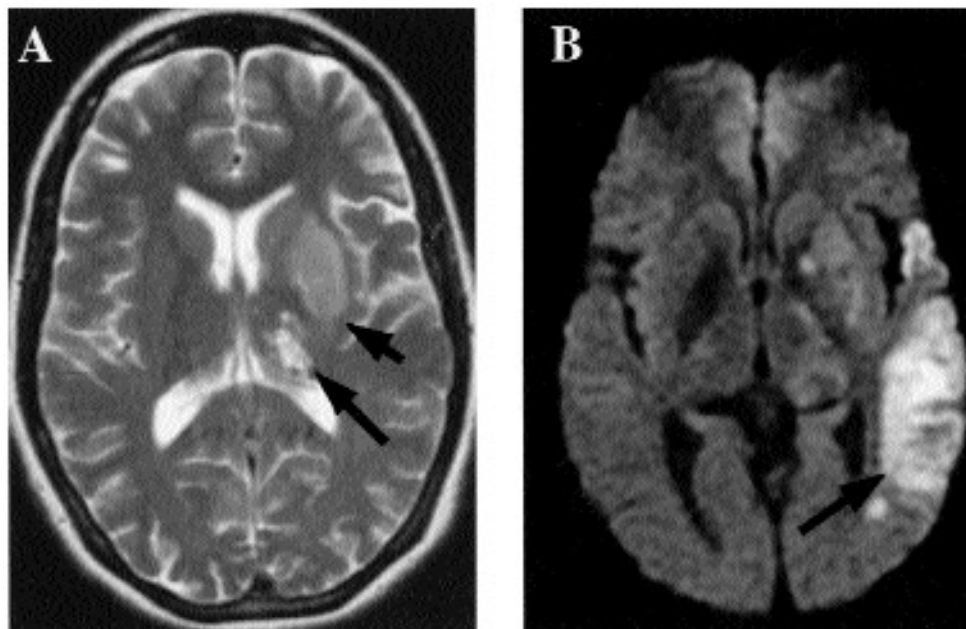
MRI of the brain showing the left lentiform nucleus (short arrow) and thalamus (long arrow) infarct (A, axial T2 weighted image); and left parietal lobe ischemia, which is prominent by diffusion imaging technique (B).
